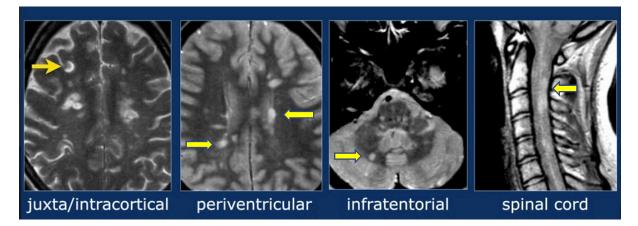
MRI images typical of MS in the locations defined by the McDonald criteria. From left to right, juxta/intracortical axial view, periventricular axial view, infratentorial axial view, spinal cord sagittal view (arrows denote lesions). (Barkhof and Smithuis, 2021)
